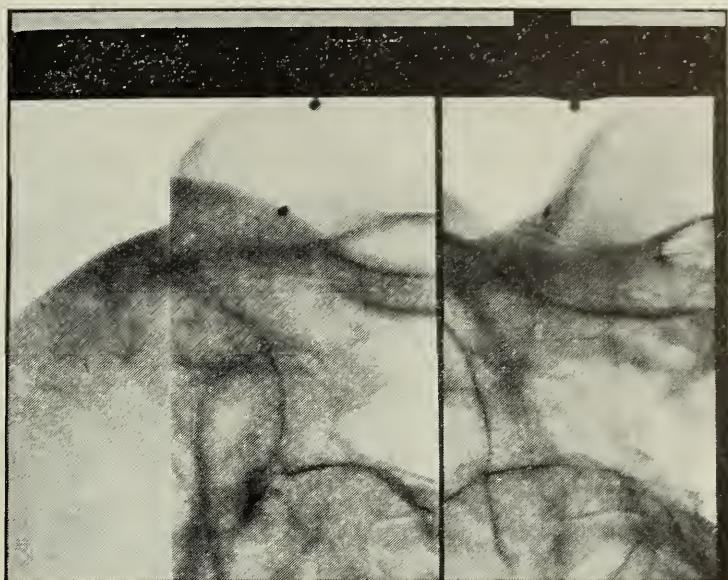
Radiograph of foreign body in eye (three-fourths actual size).
